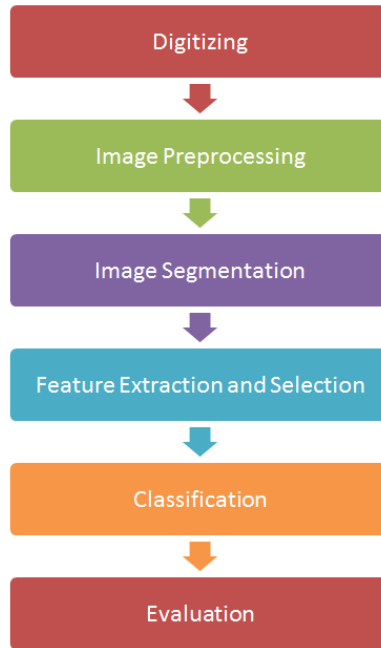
The first approach to CAD design. The proposal of [35] was designed for detection and classification of masses in mammography but can be easily applied to DCE-MRI.
